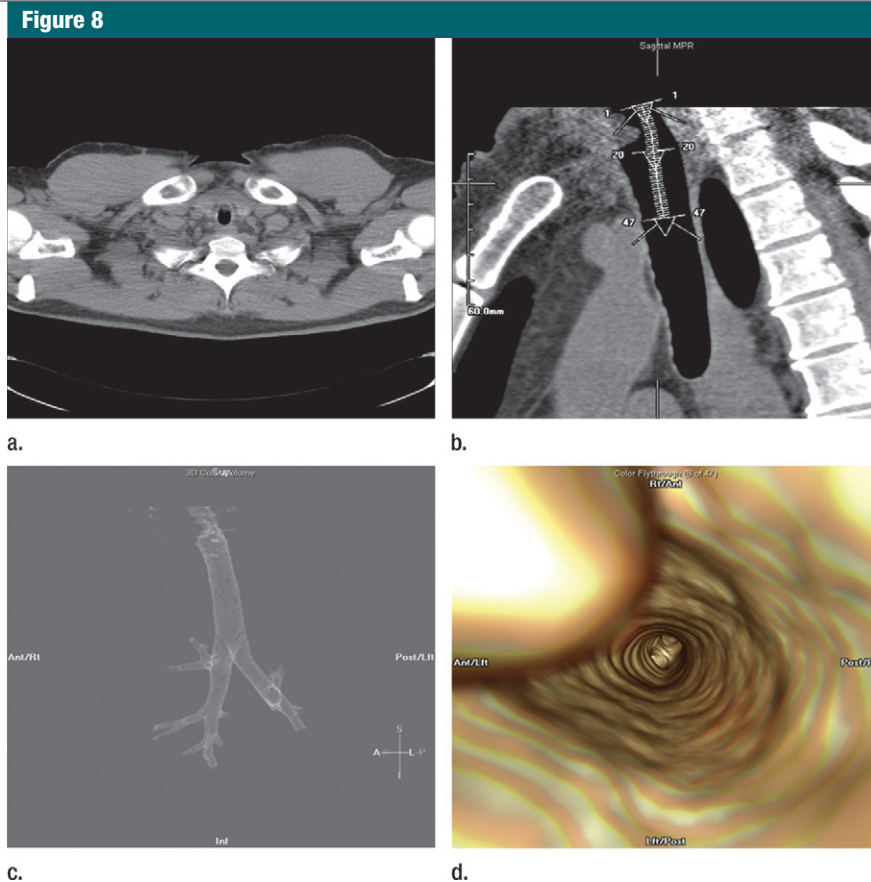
Advanced 3D and pseudo 3D displays of the central airways used in surgical planning. (a) Axial CT, (b) curved multiplanar reformation, and (c) 3D volume-rendered CT images and (d) color virtual bronchoscopic fly-through image. (Images courtesy of Ritu Randhawa Gill, MBBS, Brigham and Women's Hospital, Boston, Mass.)
